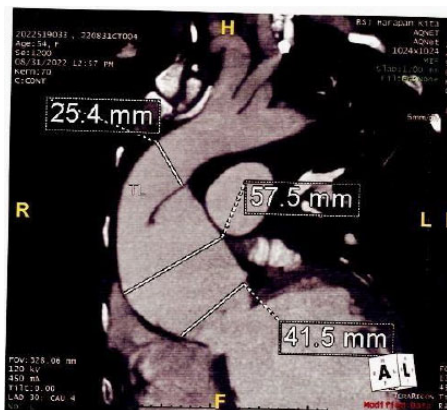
CT Angiography showed aortic root dilatation (45,1 mm), proximal ascending aorta aneurysm (57,7 mm).
